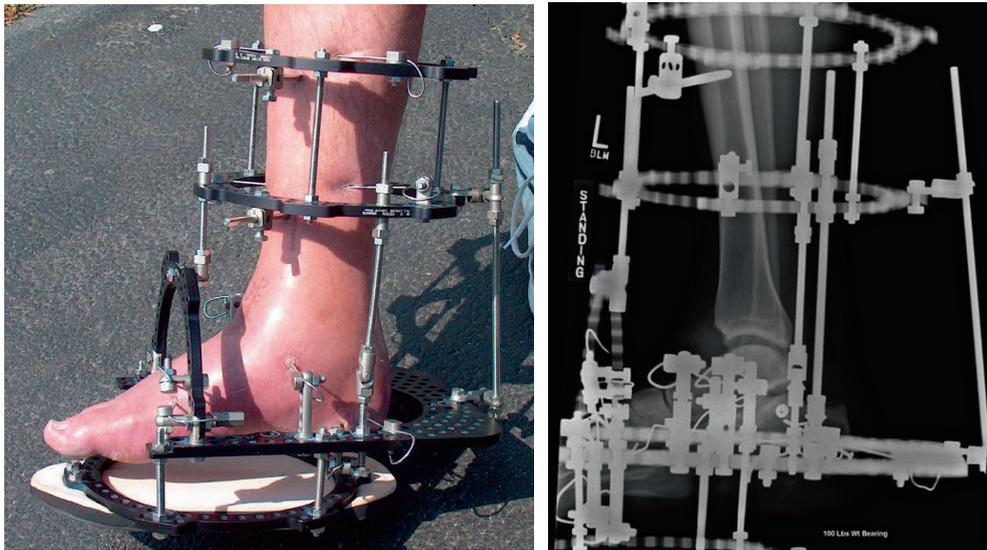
An Ilizarov external fixator was used to apply distraction to the ankle (left). Radiographic view of the distracted ankle (right).
